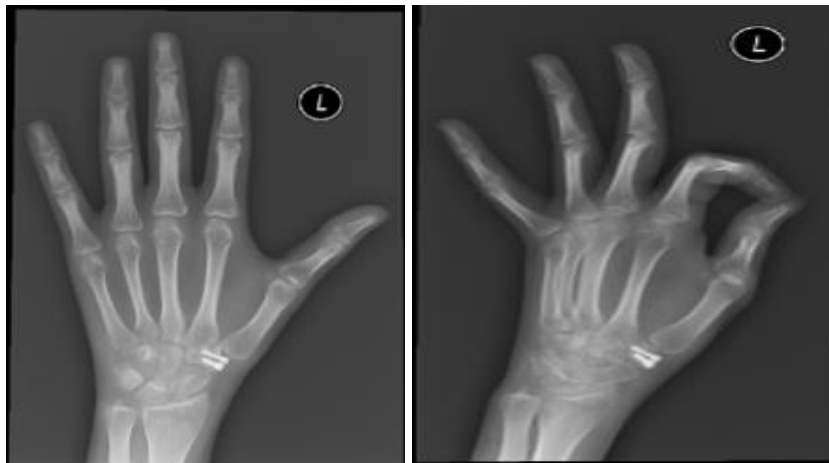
Day 1 postoperative X-ray.
